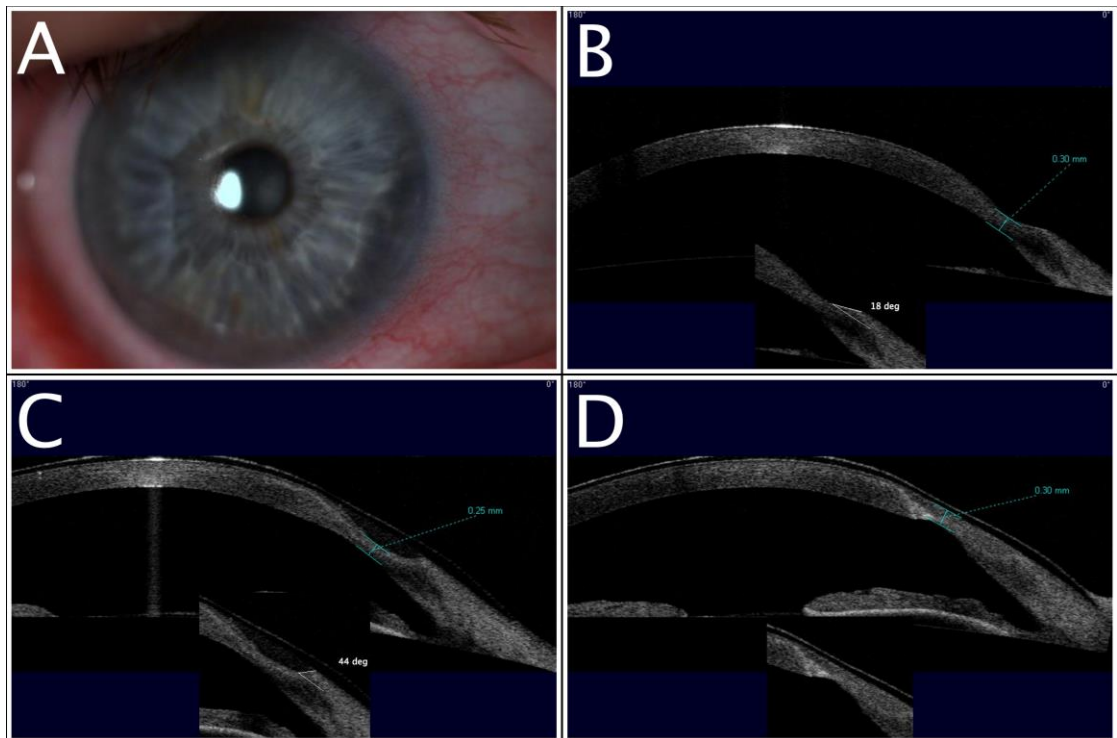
Case 4. Serial AS-OCT scans through progressive peripheral ulcerative keratitis. A. Colour photo of right eye at presentation showing conjunctival injection and nasal corneal thinning. B. The active ulcer at presentation had relatively steep walls, with the steepest wall having a gradient of 18° ; minimum corneal thickness (CT) at the ulcer base measured $300\text{ }\mu\text{m}$. C. Four days later, the gradient of the steepest ulcer wall had increased to 44° and the minimum CT had decreased to $250\text{ }\mu\text{m}$, suggesting that the corneal inflammation and melting were ongoing. D. One week later, following stabilisation with a rituximab infusion and emergency Tisseel glue application, the posterior corneal surface showed localised ectasia but CT had increased to $300\text{ }\mu\text{m}$, most likely due to the adhesive and bulking properties of Tisseel.
